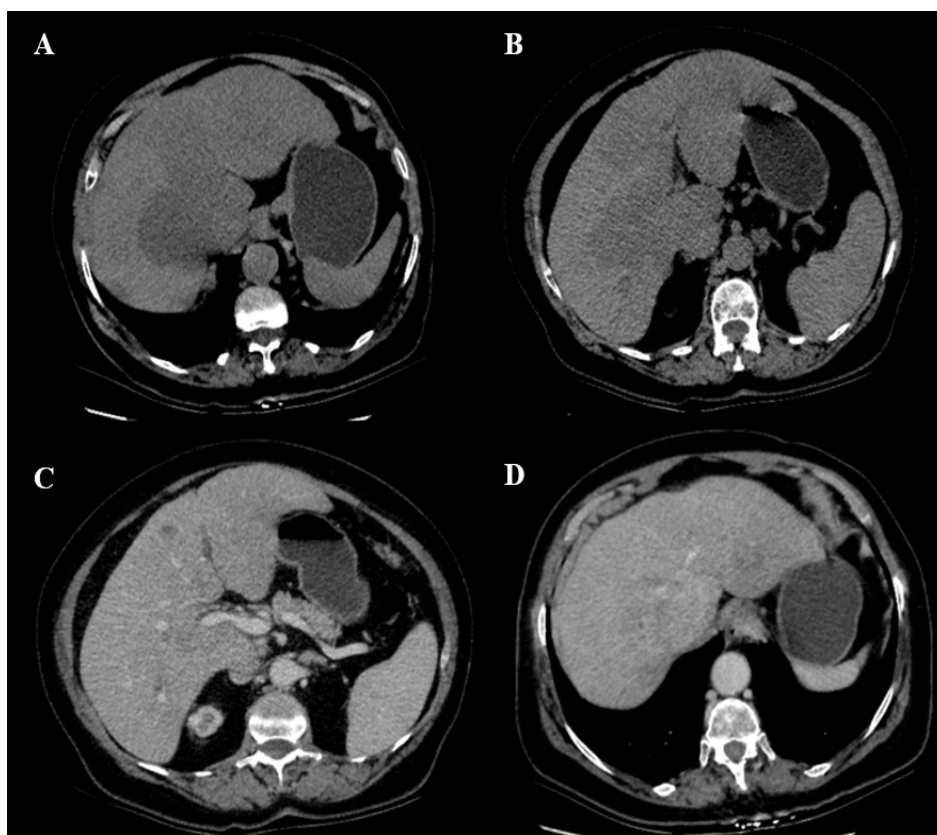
Contrast-enhanced abdominal CT scan showing low-density infiltrative liver lesions (A, B) with mild enhancement after contrast administration (C, D), compatible with diffuse metastatic involvement.
